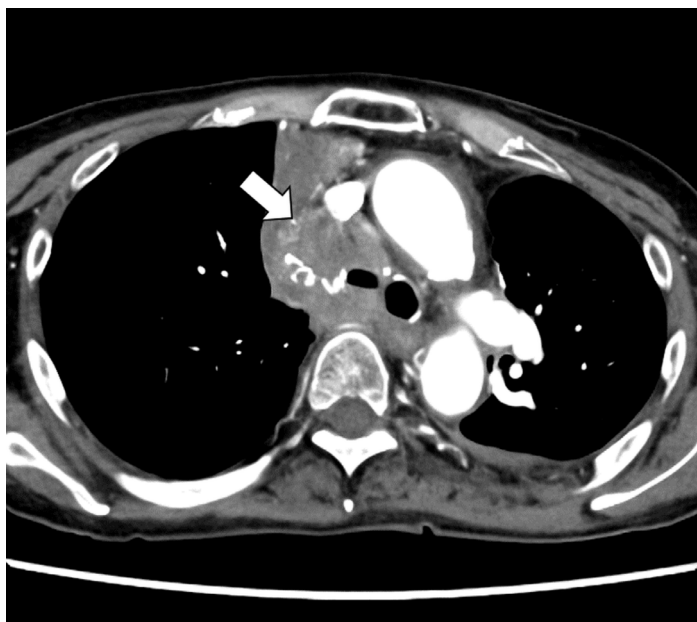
Contrast-enhanced axial computed tomography image demonstrating a mediastinal tumor associated with superior vena cava syndrome in a woman in her 60s. The mediastinal tumor is indicated by an arrow.
